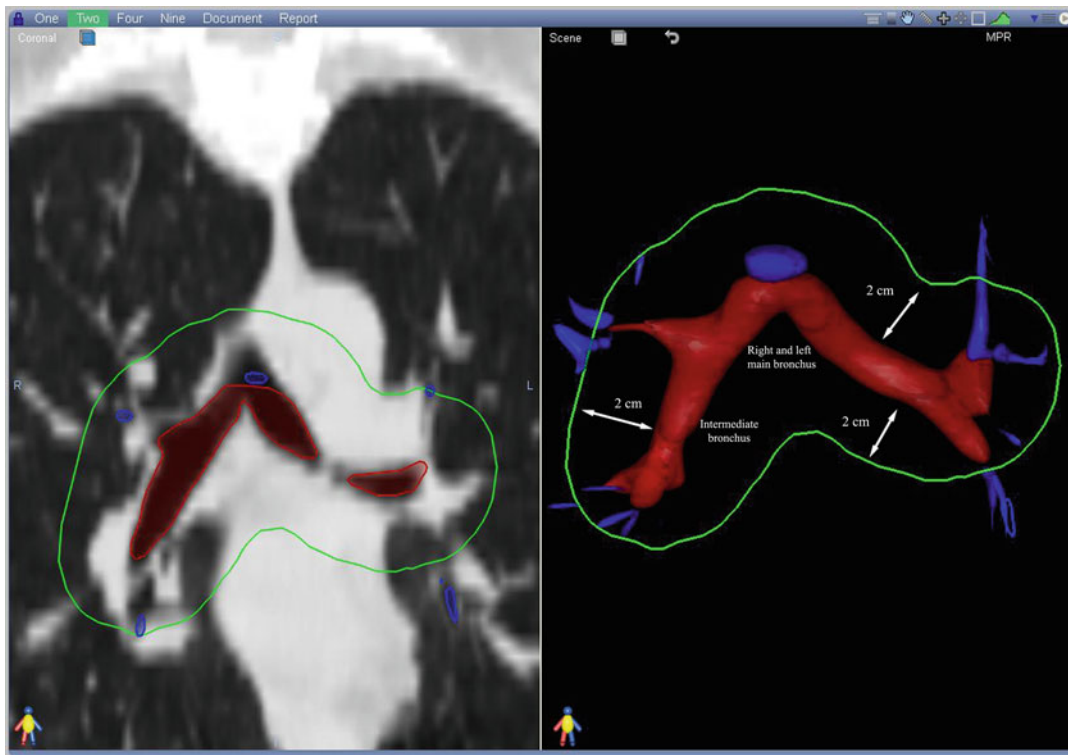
Coronal CT image with the proximal bronchial tree (carina, right and left main bronchi, right and left upper lobe bronchi, intermedius bronchus, right middle lobe bronchus, lingular bronchus, and right and left lower lobe bronchi all contoured in *red*) with a 2 cm expansion (in *green*) to produce the zone of the proximal bronchial
